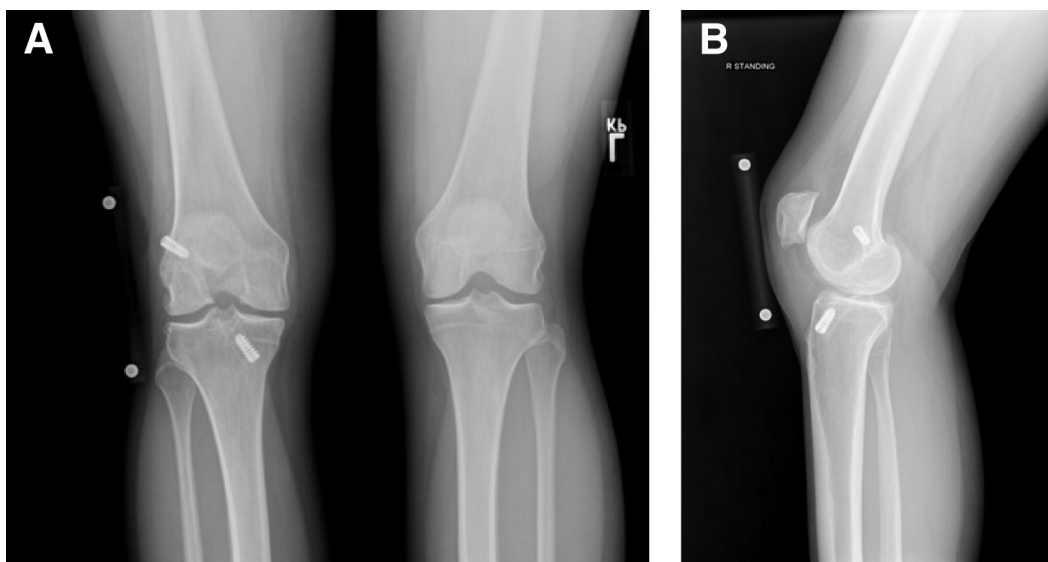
(A) Standing posterior-anterior (PA) flexion radiograph of a patient with symptomatic anterior right knee pain after previous right knee anterior cruciate ligament reconstruction with mild decreased joint space and numerous osteophytes present. (B) Lateral radiograph of the right knee in the same patient showing joint space narrowing between the patella and the distal femur.
